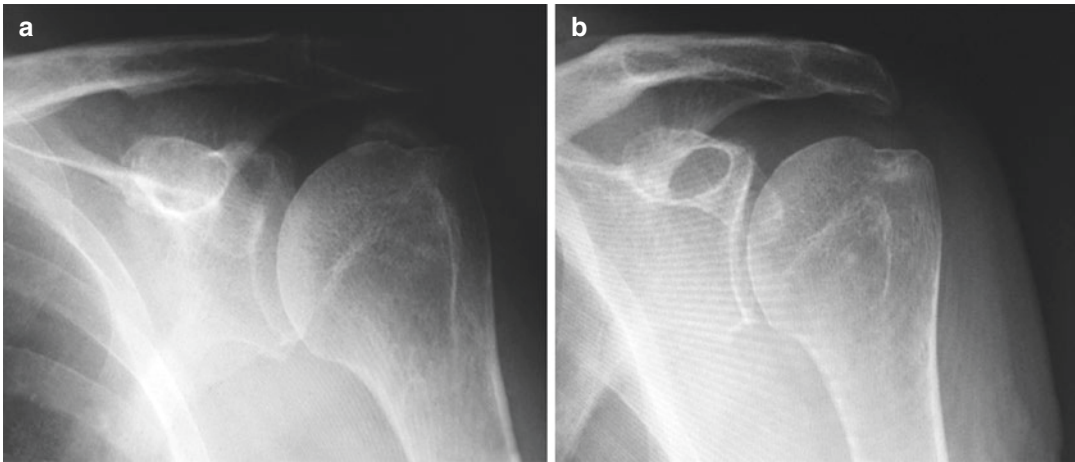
AP view of Shoulder radiography: Calcific tendonitis (a) before and (b) after Barbotage
